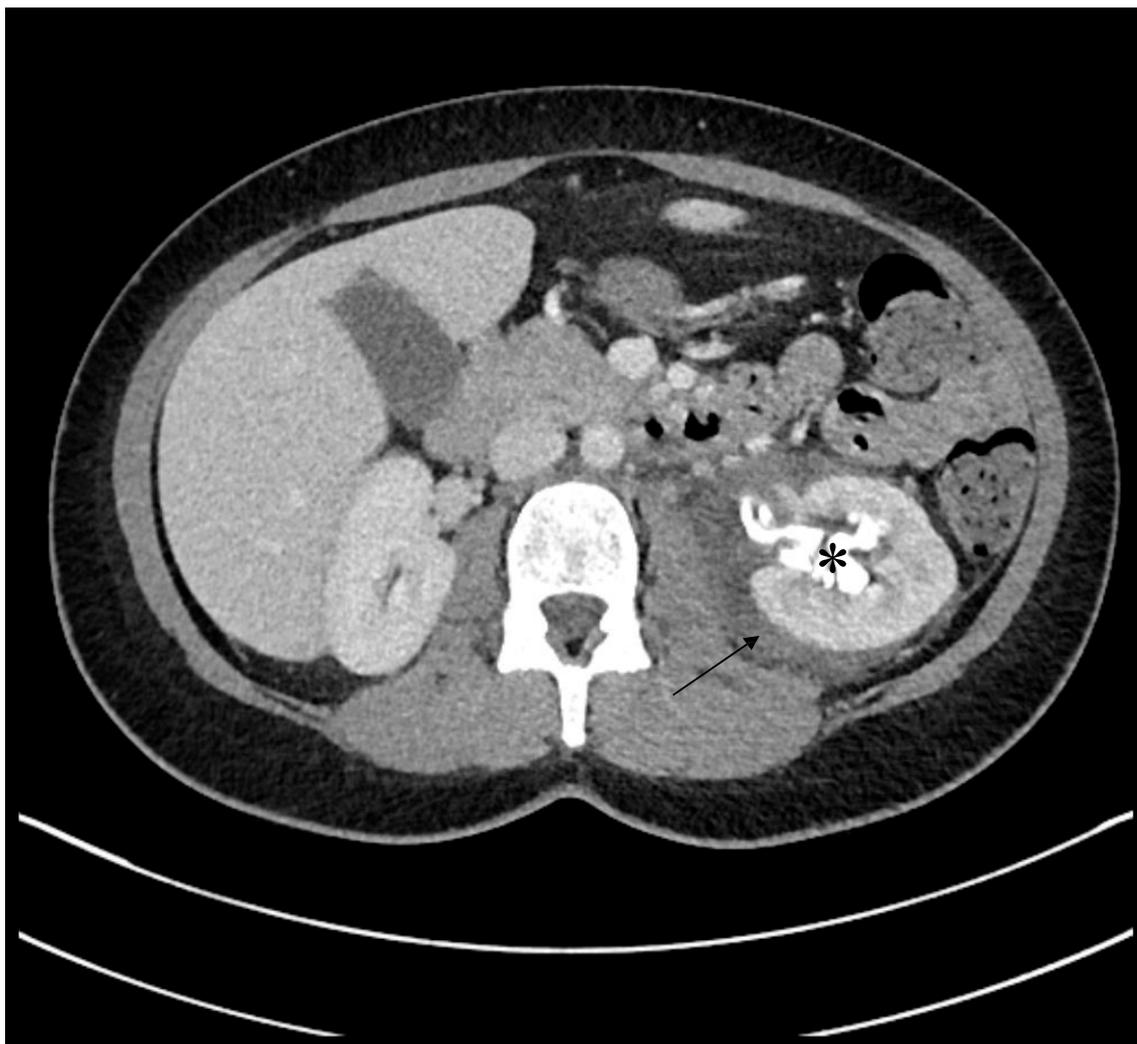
Postoperative computer tomography (CT) scan. Perirenal free fluid (arrow) as well as a leakage of contrast agent is seen exiting the left renal pelvis (*), confirming pyelon rupture of the left kidney.
